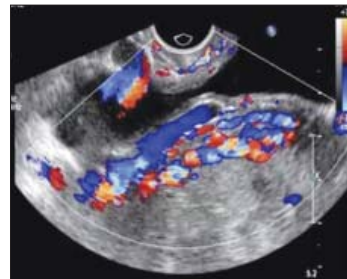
Color doppler USG showing uterovesical hypervascularity
